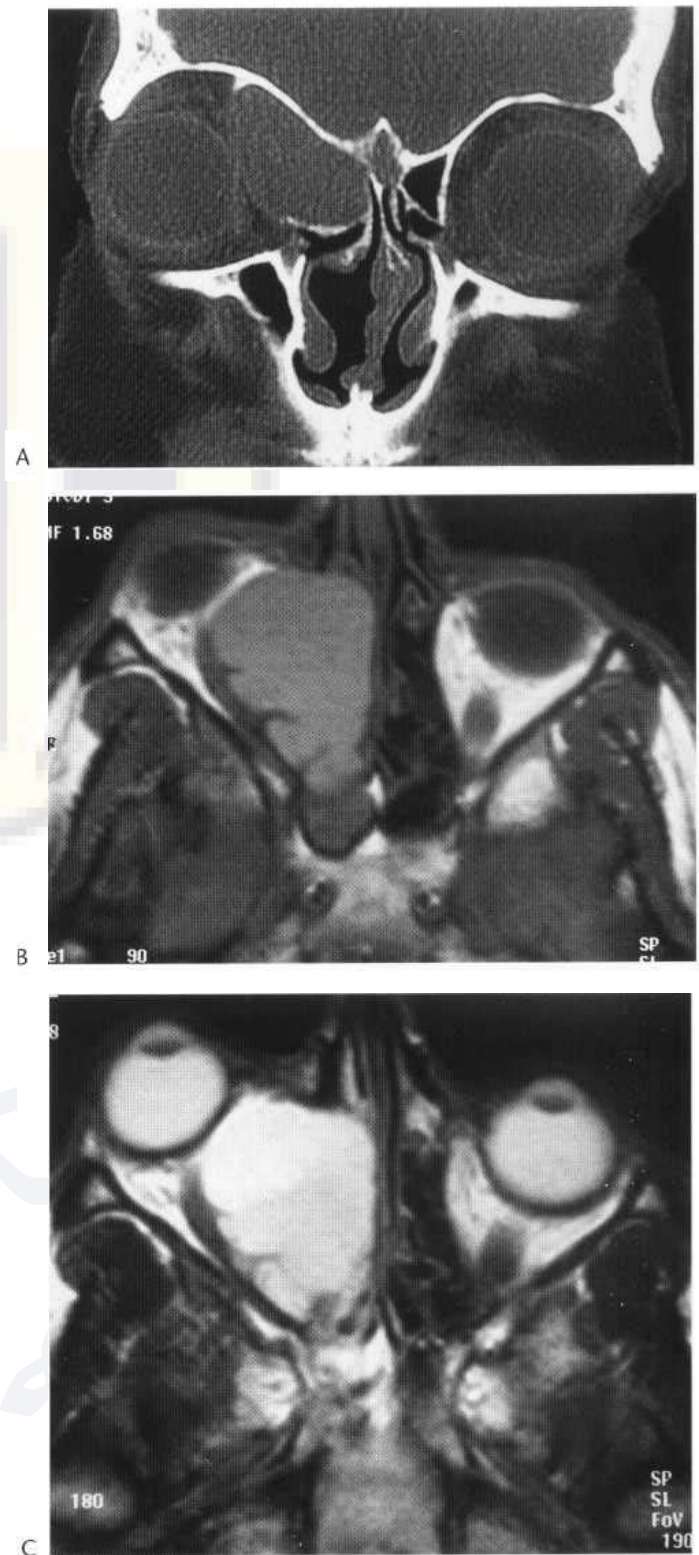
Frontoethmoid mucocele. (A) Direct coronal CT scan demonstrates expansion of the right ethmoid cells with bony expansion and a mass which extends into the right orbit. (B) Axial T₁-weighted and (C) axial T₂-weighted MRI scans show expansion and scalloping of the bony margins with extension into the right orbit.
